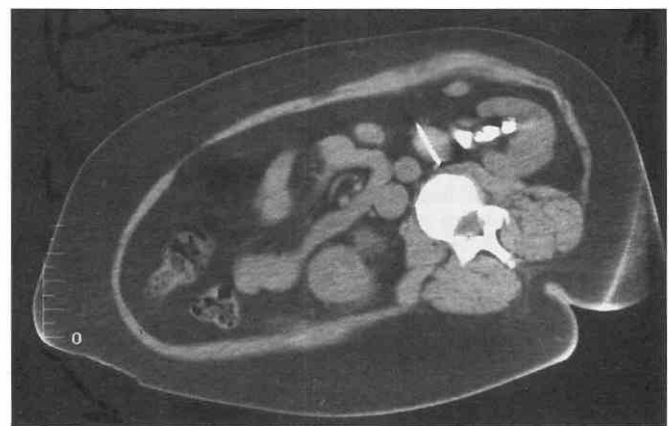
CT-guided ablation of a retroperitoneal lymph node. An approach through the anterior abdominal wall was used because this was the shortest unimpeded pathway.
